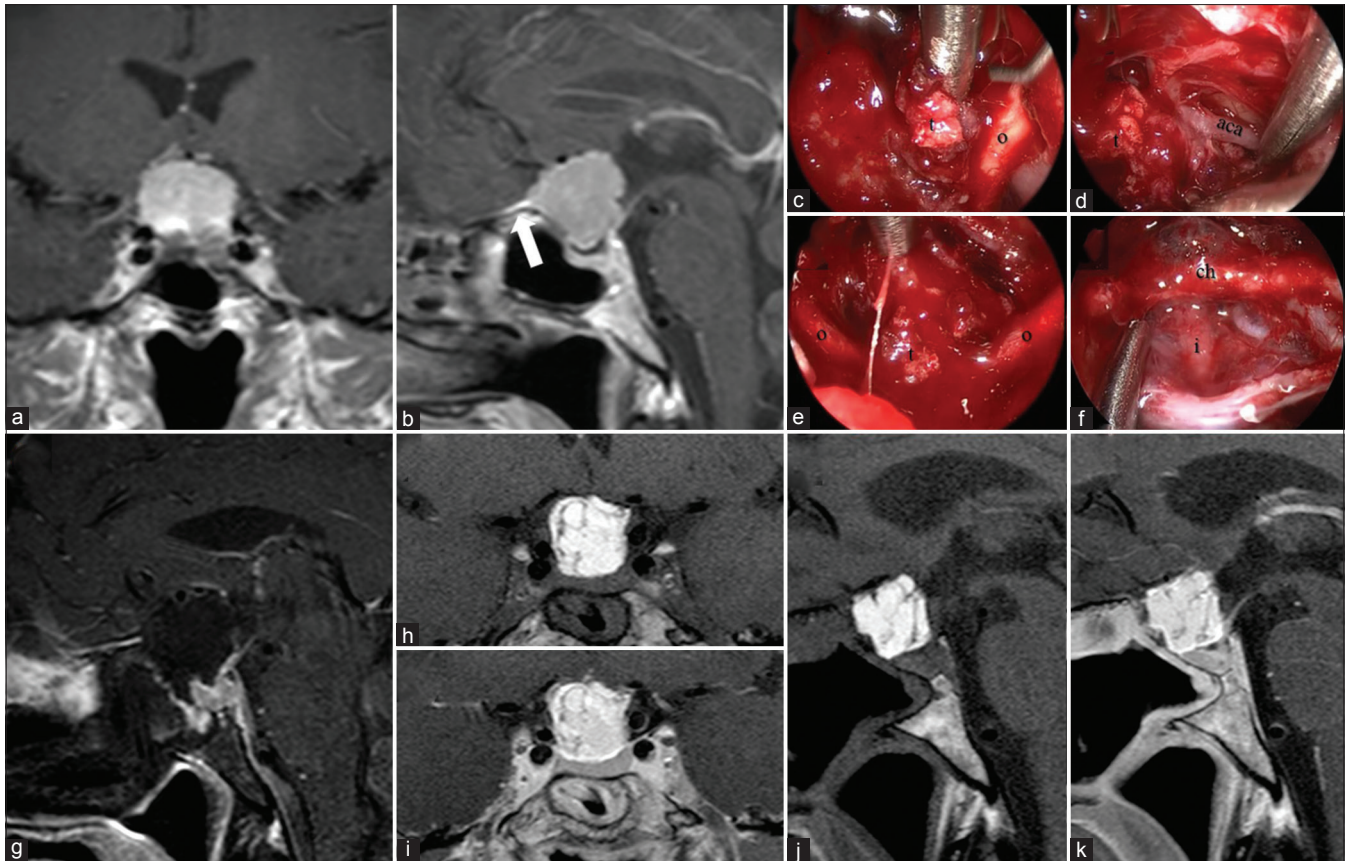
A 65-year-old female with gradual visual deterioration. The preoperative T1 MRI with gadolinium (a and b) demonstrated an extra-axial mass arising from the tuberculum sella dura with dural tail (white arrow). The patient underwent an endonasal endoscopic transplanum, transsellar skull base approach for resection of the mass. Pathology was consistent with a benign meningioma. Intraoperative views (c,d,e,f) of tumor (t) removal with separation away from the optic nerves (o), chiasm (ch), anterior cerebral artery (aca), and infundibulum (i). The immediate postoperative T1 MRI with fat suppression and gadolinium (g) demonstrated a GTR of the tumor. The 3-month postoperative T1 MRI without gadolinium (h and j) and with gadolinium (i and k) demonstrate fat graft in the resection cavity without evidence of tumor recurrence
